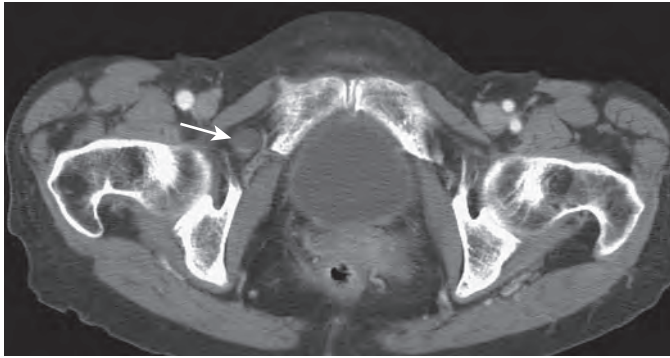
Obturator hernia. Pelvic CT reveals a small knuckle of ileum in a hernia (arrow) deep to the right pectineus and anterior to the right obturator internus muscles.
